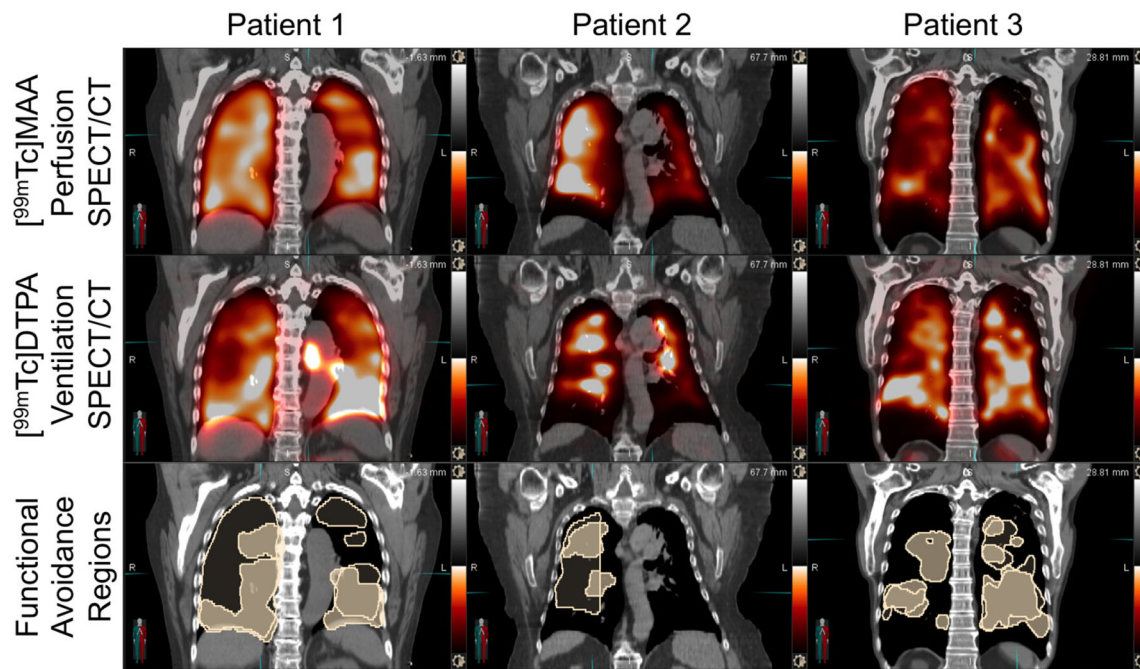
SPECT/CT imaging of perfusion and ventilation for functional lung definition. *Top* three patients display non-uniform uptake of ^{99m}Tc -MAA lung perfusion. *Middle* ^{99m}Tc -DTPA lung ventilation. *Bottom* avoidance regions were defined by a gradient search
